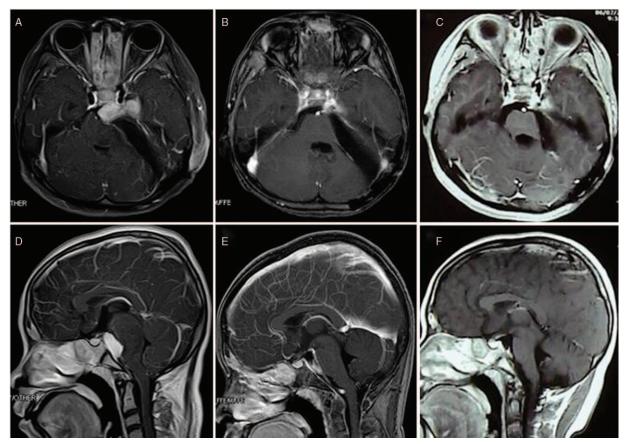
(A, D) Repeated T1-weighted contrast-enhanced MRI scan at the 2nd day after the operation showing residual lesion in the left petrous apex and cavernous sinus. The residual lesion significantly retrogressed on follow-up images at 4 months (B, E) and 12 months (C, F) after gamma-knife treatment.
